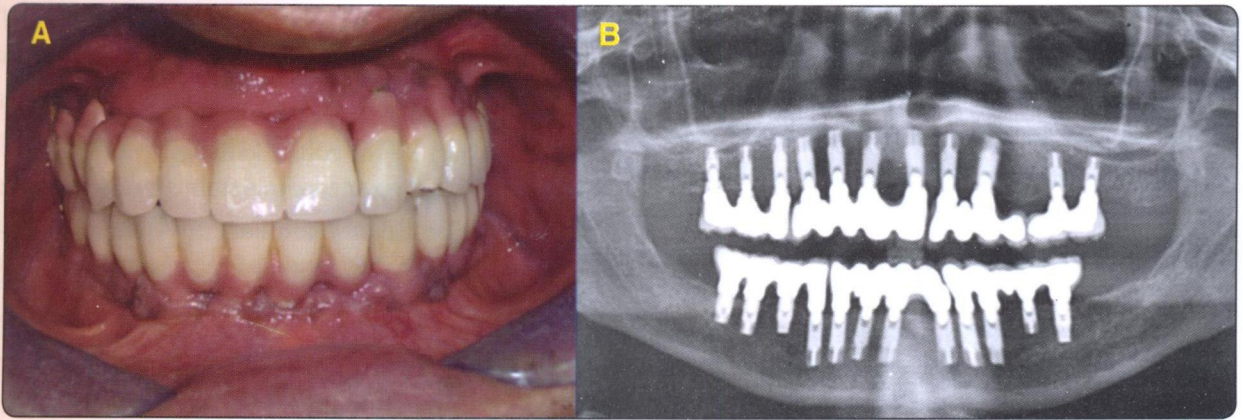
(A) Post operative intraoral view after six years (B) Panoramic radiograph after six years of follow up.
